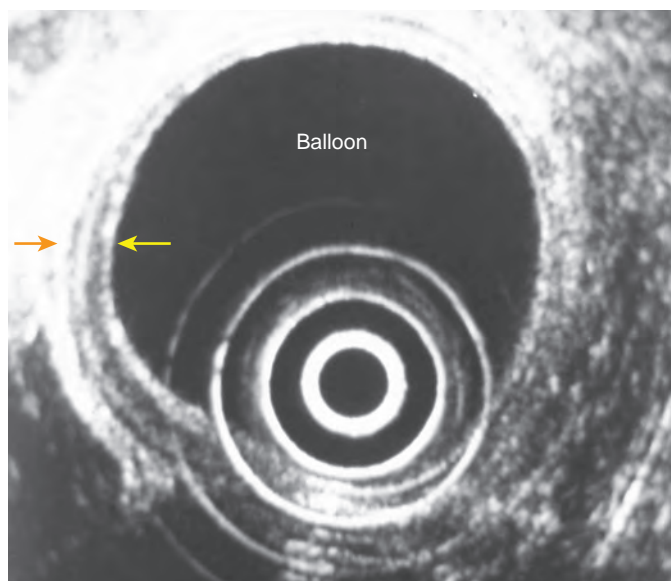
Normal endoscopic ultrasound. This image shows all five layers (arrows) of the esophageal wall.
